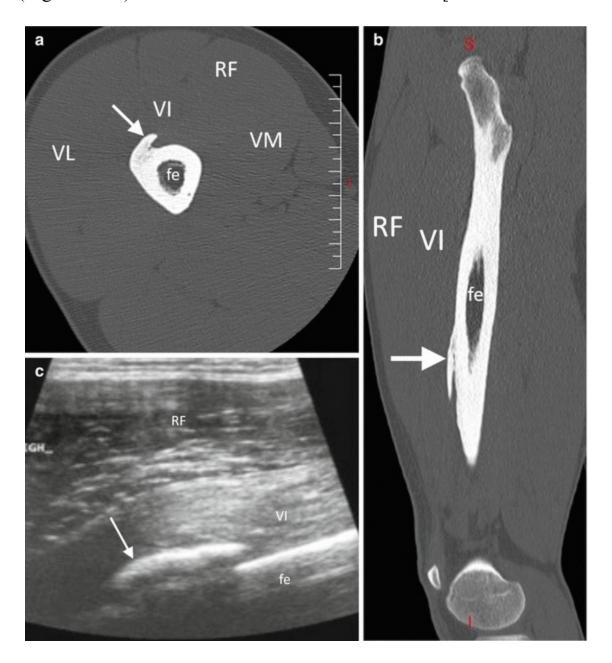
Axial (a) and sagittal reformatted (b) CT images demonstrate chronic coalescence of the ossification (arrow) from the vastus intermedius with femur cortical bone at the mid third of the anterior thigh in keeping with myositis ossificans traumatica. Longitudinal ultrasound image (c) at the mid third of the anterior thigh shows hyperechoic linear structure with shadowing effect due to myositis (arrow). RF rectus femoris, VI vastus intermedius, VL vastus lateralis, VM vastus medialis, Fe femur
